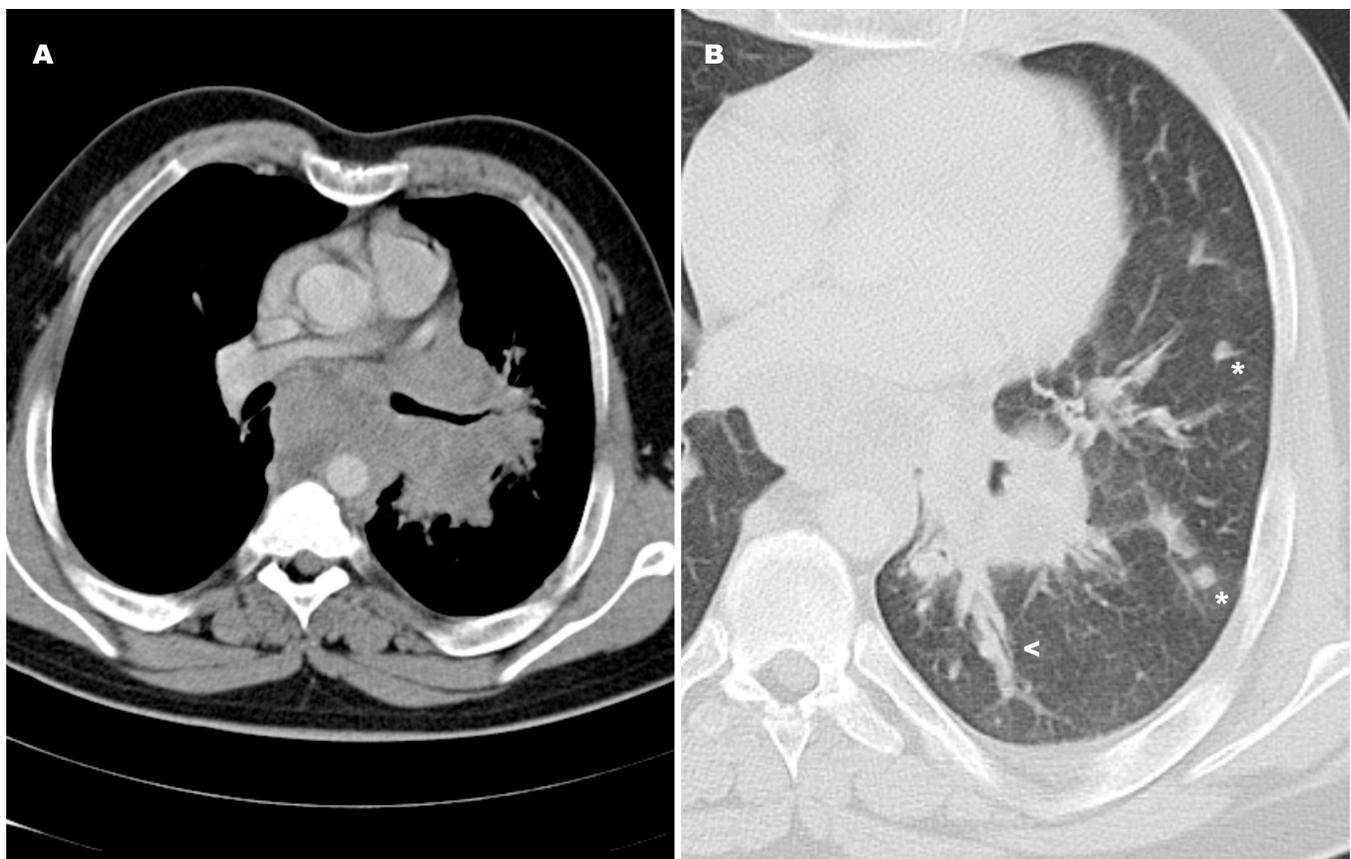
Contrast-enhanced computed tomography of Case 2
